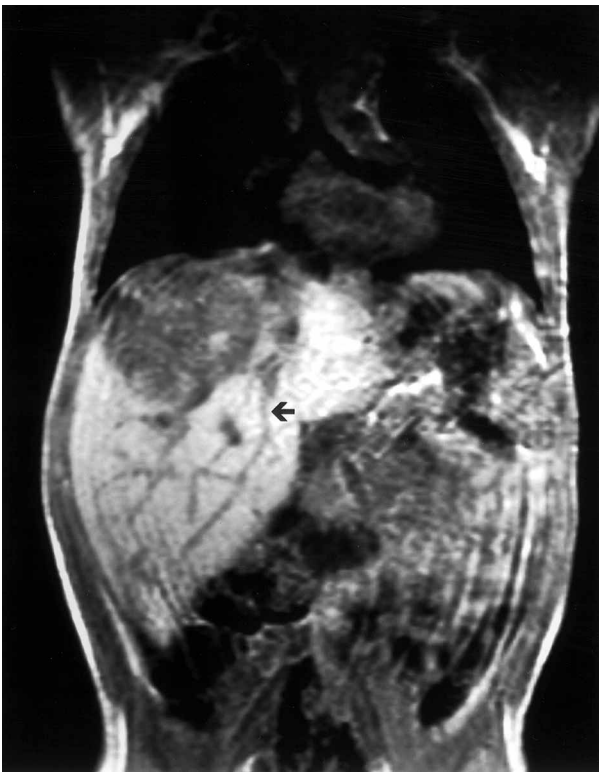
Preoperative coronal post-gadolinium T1-weighted MRI scan of a 16-month-old infant with hepatoblastoma, demonstrating absence of flow within all three hepatic veins, tumour encroachment on the inferior vena cava, and a large tumour mass occupying the superior segments of the liver. The arrow marks the presence of a prominent inferior accessory hepatic vein.
